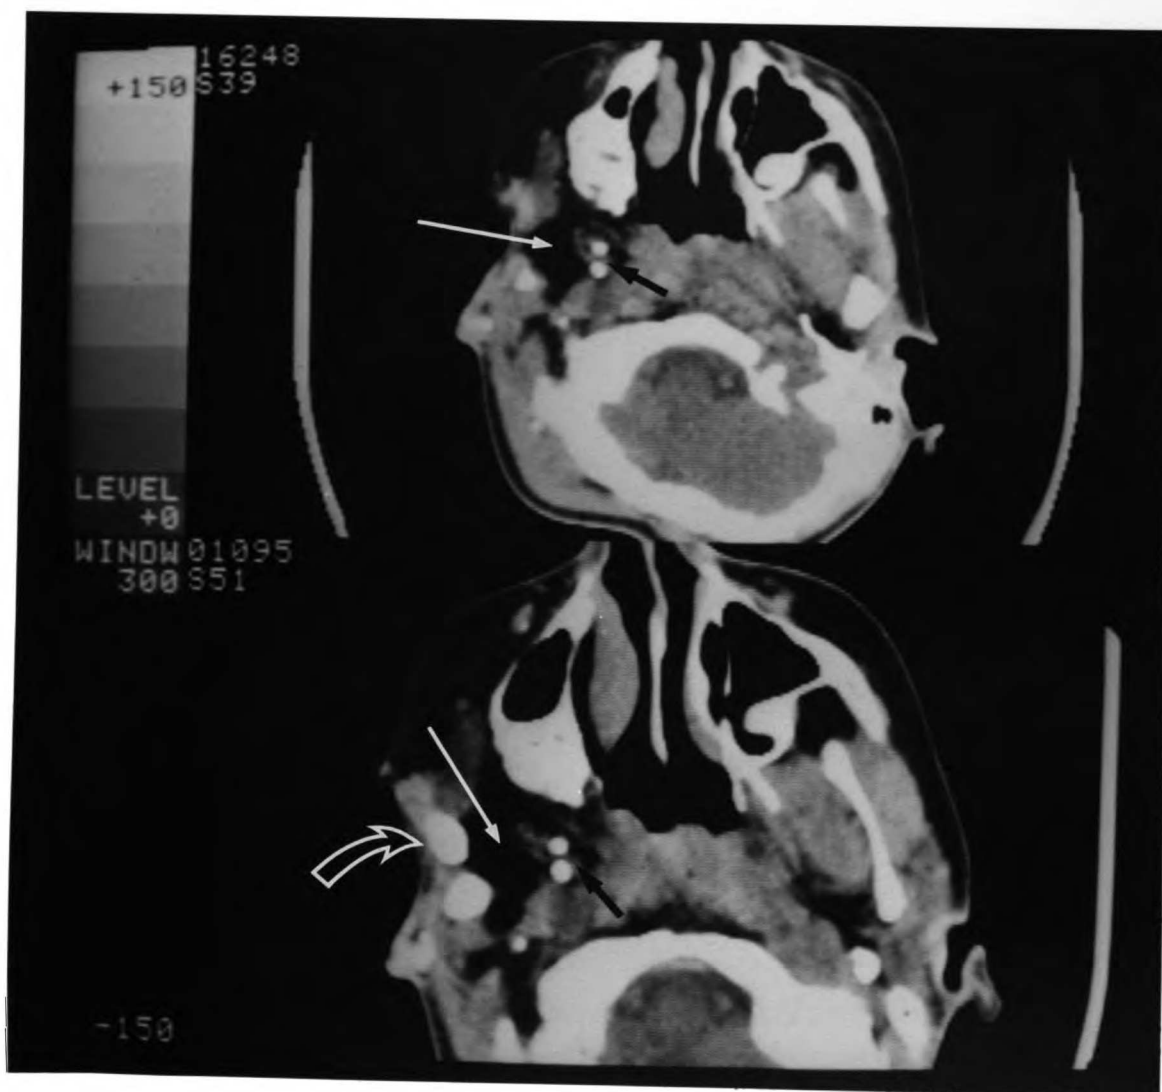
Two axial CT images in matched format of the same patient. These images are from HFM patient #1 at the level of the nasal cavity; pre-tx image is above and post-tx image is below. Solid white arrows indicate an area of poorly vascularized adipose tissue in the area of the missing mandibular ramus. Outlined white arrow points to a costochondral bone graft. The right masseter muscle can be seen just anterior to the graft. Black arrows indicate two unidentified calcified structures (see text).
